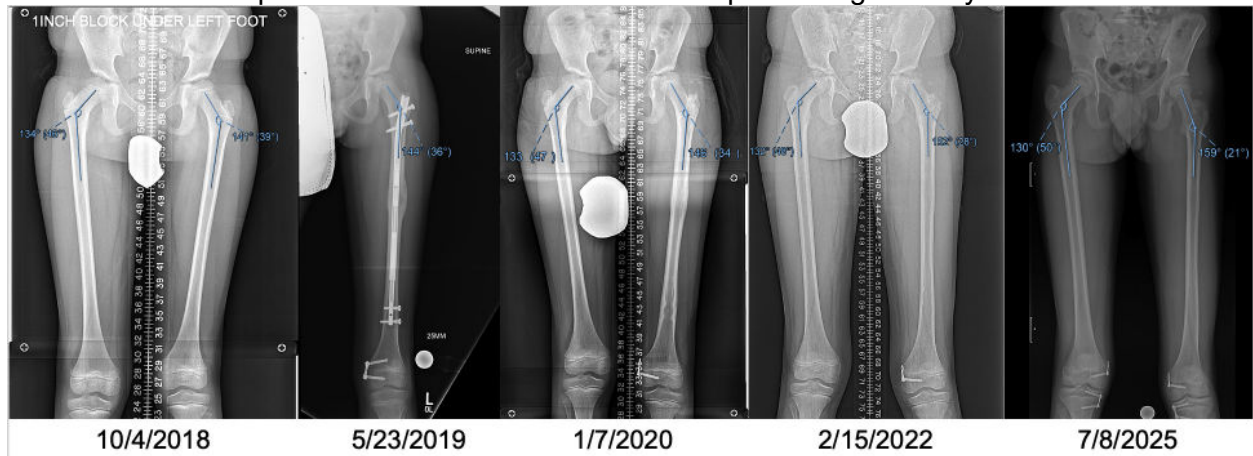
Radiographic changes for one patient who developed coxa valga after insertion of intramedullary lengthening nail. From pre-operative (10/4/2018), there is a progressive increase in NSA of the left hip from 141° to 159° at latest follow-up at the age of 15 years.
